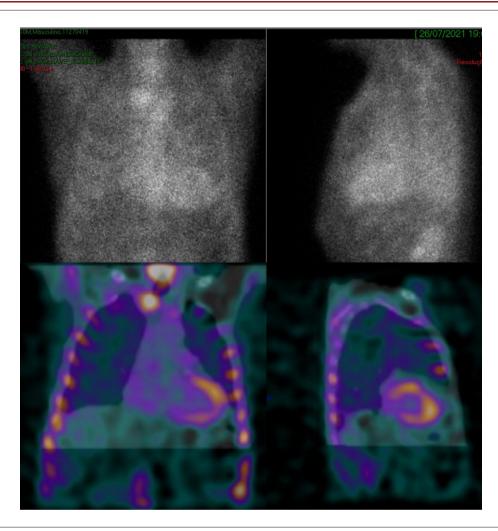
Myocardial pyrophosphate scintigraphy with planar images (upper quadrants) and SPECT (lower quadrants), showing increased cardiac uptake in relation to the contralateral chest, with similar intensity to that of the costal arches (grade 2).
